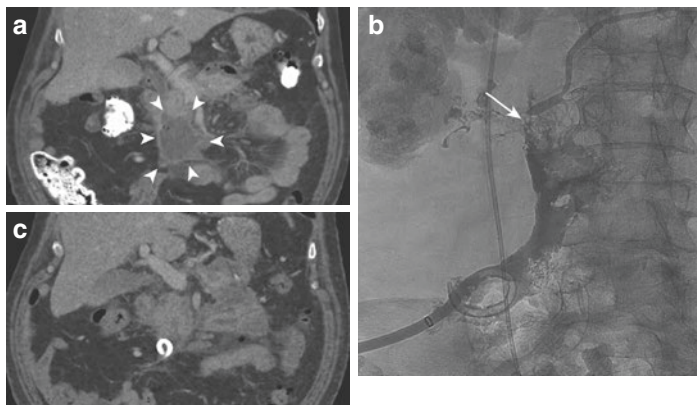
A 66-year-old male with severe acute necrotizing pancreatitis. (a) An abdominal computed tomography shows peripancreatic fluid collection localized inferiorly to pancreatic head. (b) A fistulogram drain study showed communication of contrast from peripancreatic fluid collection through main pancreatic duct (*arrow*). (c) Tip of the drain was placed at the site of pancreatic duct disruption
